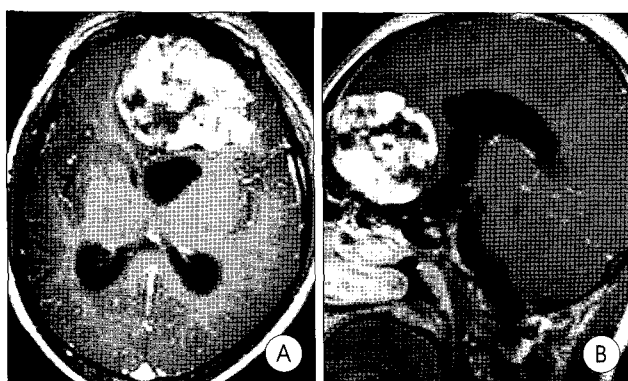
Brain magnetic resonance imaging(axial and sagittal contrast-enhanced T1-weighted images) show an extra-axial mass with intense and heterogeneous enhancement in the left subfrontal area.
